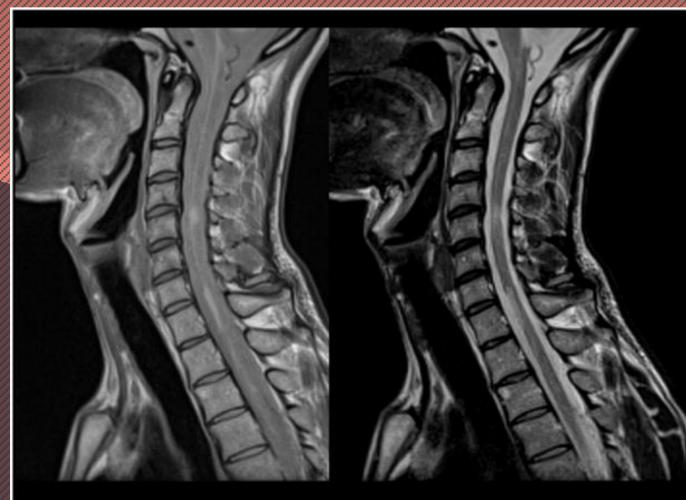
Sagittal intermediate and T2-weighted dual echo fast-spin echo images of the spinal cord in a patient with MS. Note the presence of abnormalities both at the cervical and thoracic level of the cord.<sup>7</sup>
